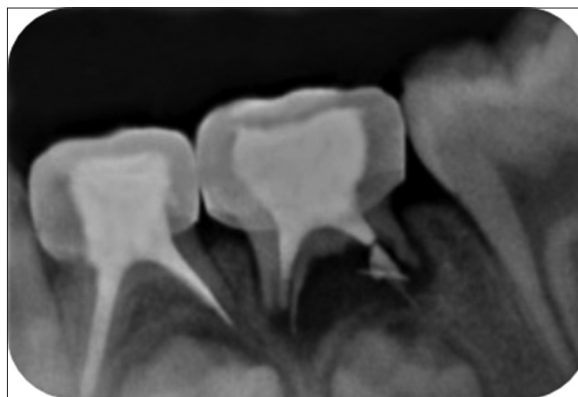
Periapical radiograph at the 3<sup>rd</sup> follow-up (9 months)
